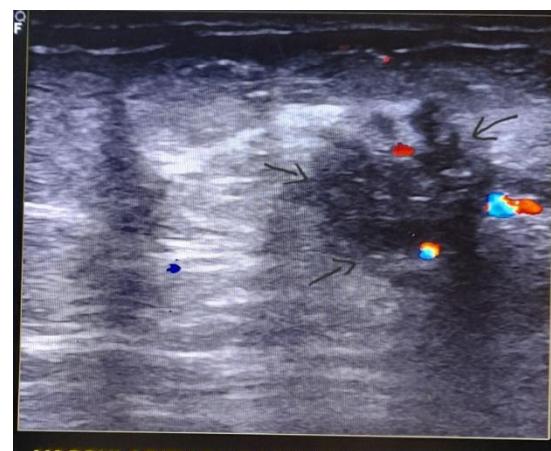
Doppler ultrasound with arterial flow
